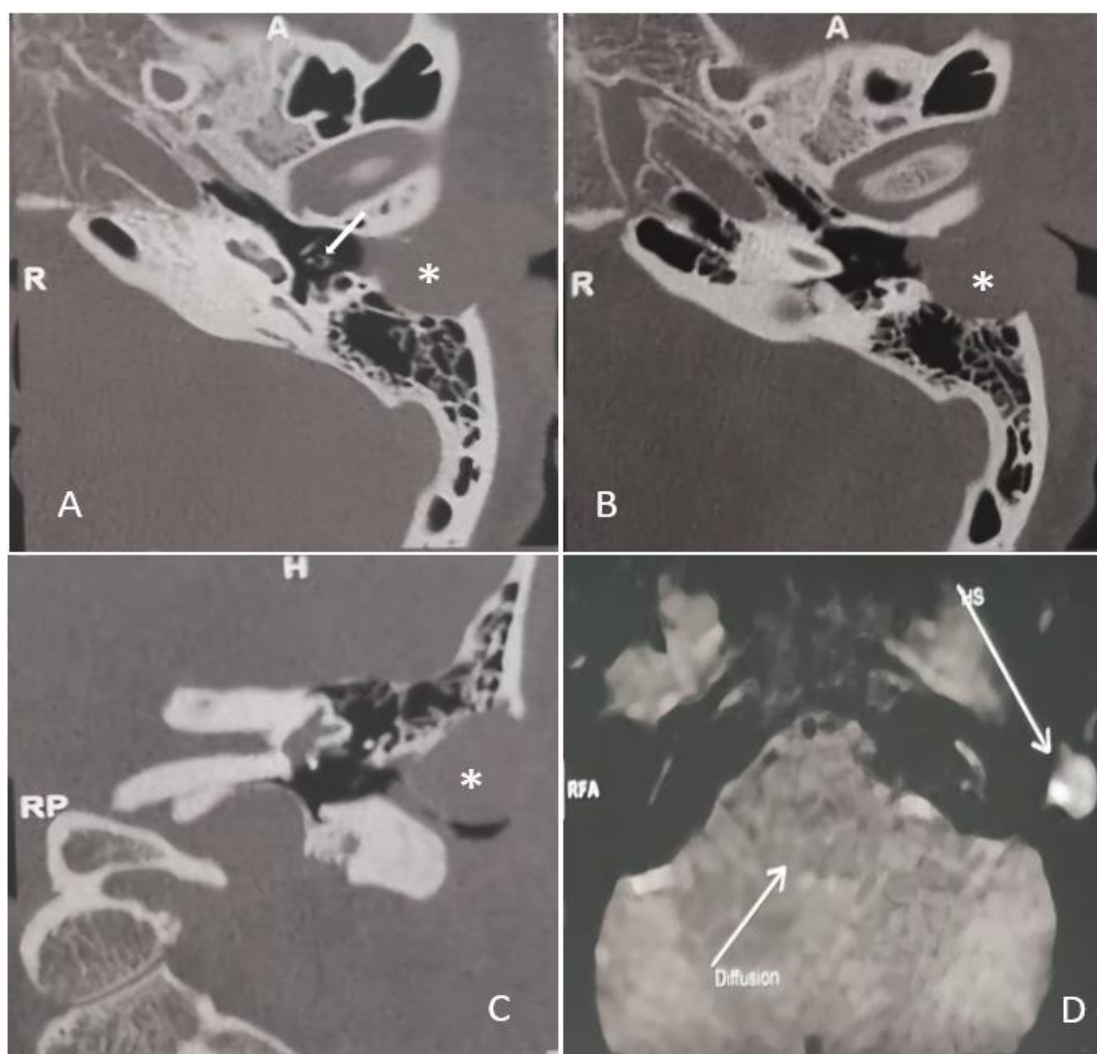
Imaging of the EECC. A+B: Axial sections of the left temporal bone HRCT showing the soft tissue density lesion in the EAC (*) with invasion of mastoid cells. The white arrow shows the loop of dislocated piston prosthesis. C: Coronal HRCT section showing the lesion (*) and invasion of mastoid cells. D: DW-MRI showing hyperintense lesion in the EAC (Diffusion) and dislocated piston prosthesis (MS).
